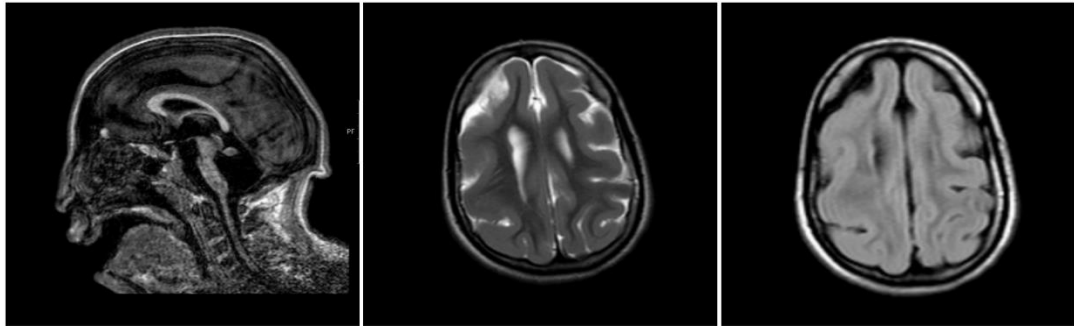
T1-weighted sagittal (left), T2-weighted axial (middle), and FLAIR axial (right) brain MRI images of patient NG2021-2
